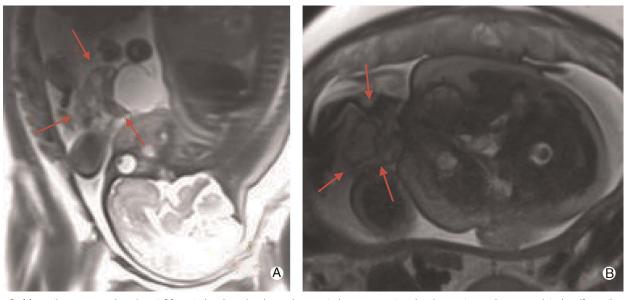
Magnetic resonance imaging at 36 gestational weeks showed no central nervous system involvement or serious associated malformations. The arrows indicate the mass. A Sagittal section. B Coronal section.
